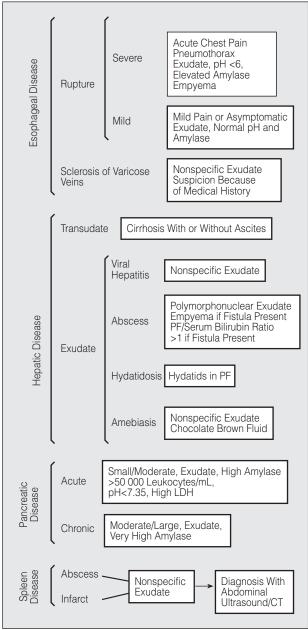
Digestive diseases that cause pleural effusion. PF indicates pleural fluid; LDH, lactate dehydrogenase; and CT, computed tomography.
